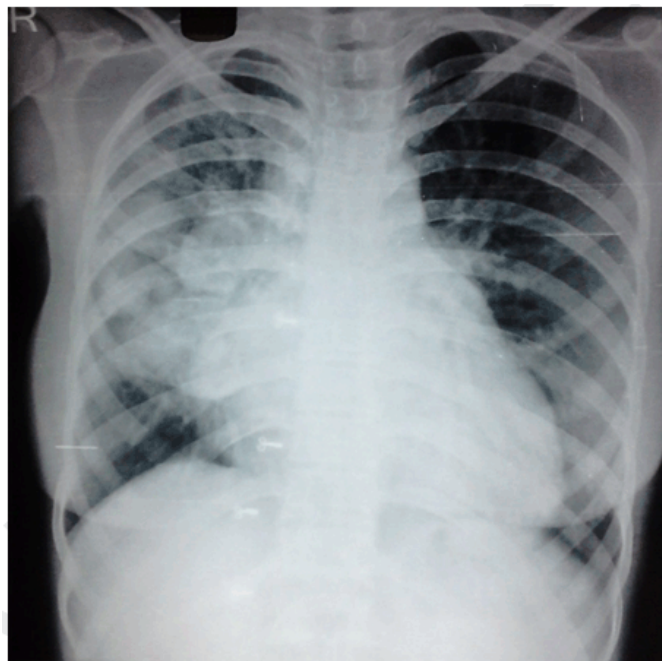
Chest X-Ray showing multi-lobulated opacity in right mid and lower zone. Cystic changes in right upper zone can be appreciated.
